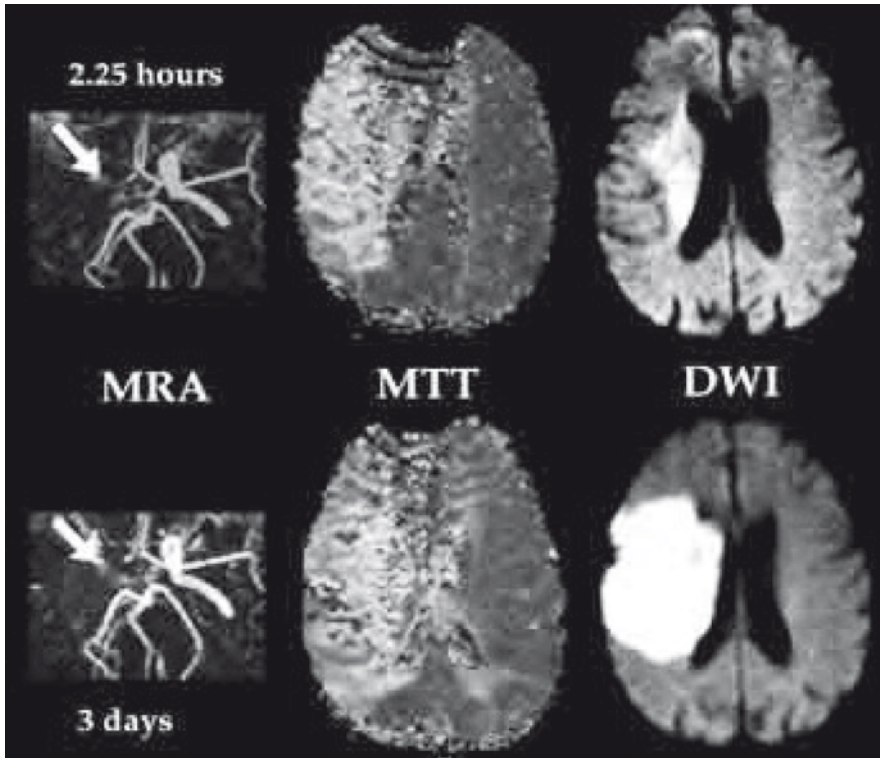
PWI/DWI mismatch can be used to identify the presence of penumbral tissue. Initially (2 h post ictus) a large perfusion deficit (MTT) and small DWI lesion suggest the presence of large penumbral region. In the absence of reperfusion or other affective therapy, ischemic lesions mature into large irreversible infarcts as indicated by a significant reduction in perfusion-diffusion mismatch. Figure courtesy of Prof. Joanna Wardlaw, University of Edinburgh, Edinburgh, UK
